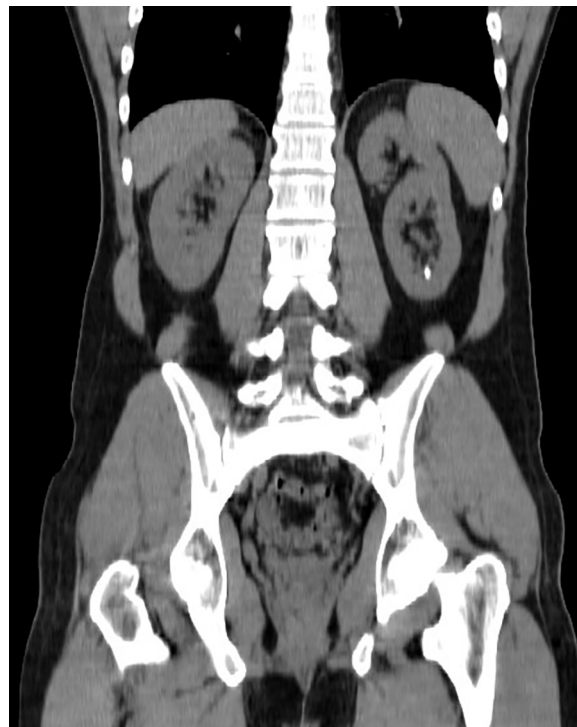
CT (Plain) 8×6 mm left renal calculus in the lower pole.
